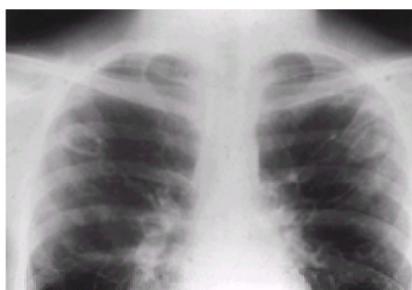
Chest radiograph of a patient with cystic pulmonary lesions caused by PCP.
